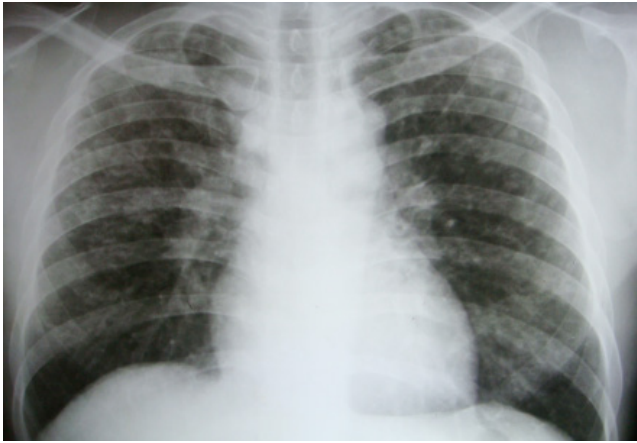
PA view of Chest X-Ray showing multiple nodular opacities in both the lung fields with right hilar and paratracheal lymphadenopathy. B. Same patient's Chest X-ray after 1.5 months of treatment. X-ray shows faint reticulonodular shadows in bilateral upper and mid zones with normal hilar shadow
